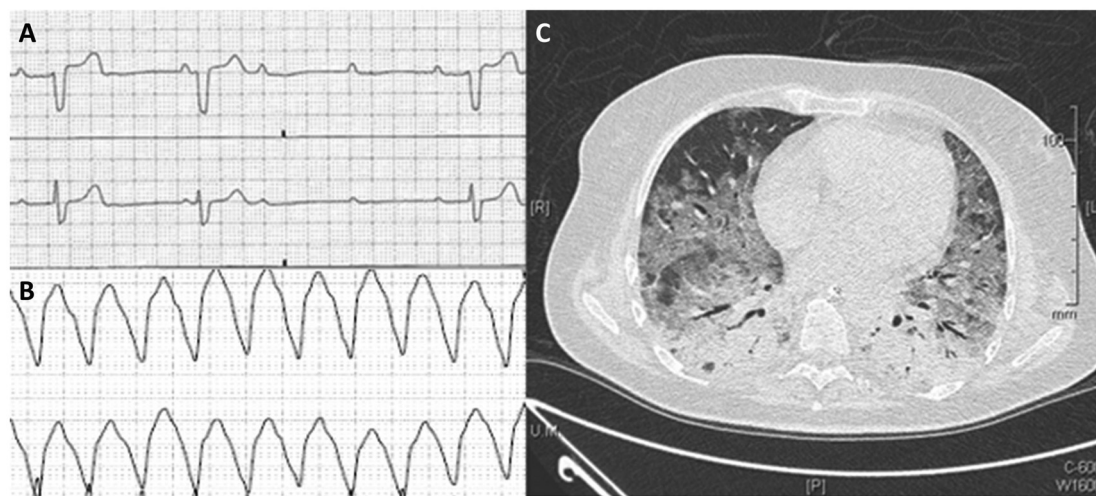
Representative depictions of complete atrioventricular-nodal block (A), monomorphic ventricular tachycardia (B) and typical computed tomographic imaging findings in a 50-year-old female patient with coronavirus disease 2019-induced acute respiratory distress syndrome (C).
